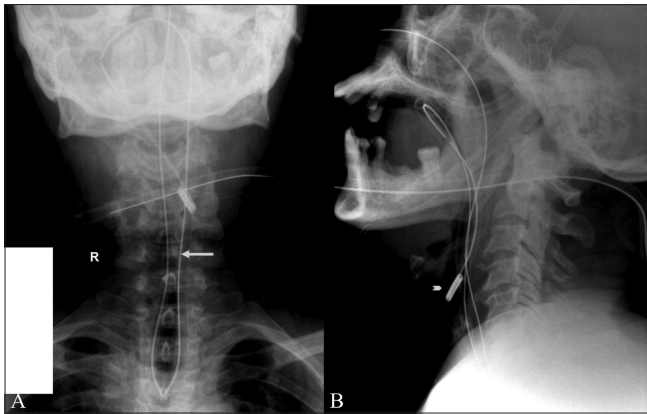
(A, B): Frontal (A) and lateral (B) radiographs of the neck show a NG tube (arrow) coiled in the upper esophagus with its tip in the oropharynx (arrowhead)
